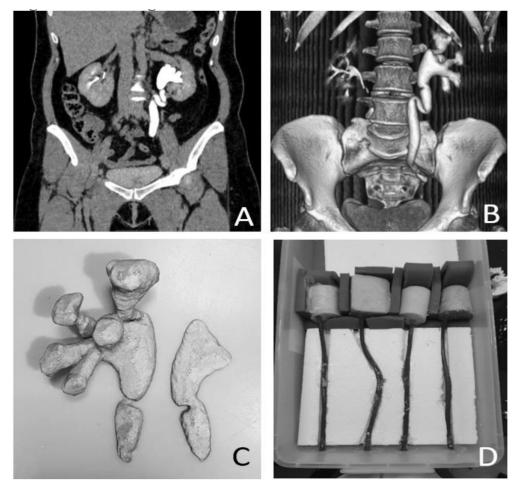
CT urogram and RIRS box. A) CT urogram, B) 3D reconstruction for printing, C) Posterior view of 3D printed model, D) RIRS box
